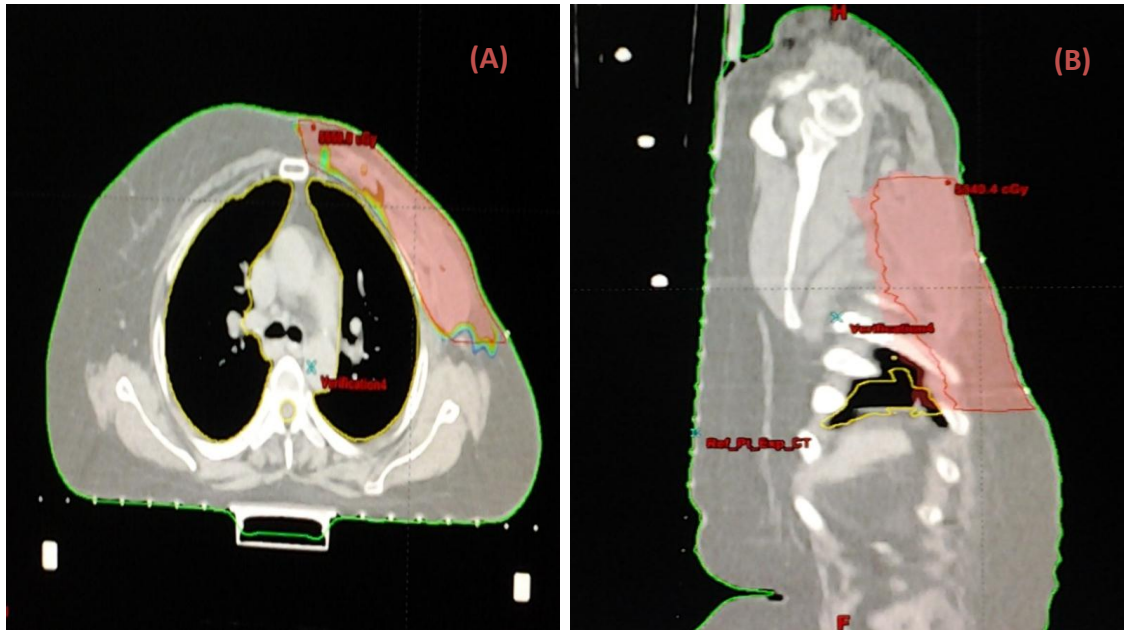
a&b: Shows the 95% isodose colour wash in axial and sagittal section at the level of carina and head of humerus respectively on Normal Expiration CT scan with IMRT
